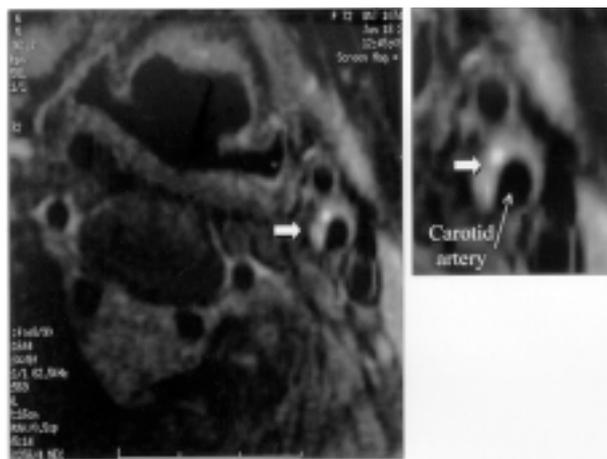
Magnetic resonance image of the left internal carotid artery: a triple inversion recovery-prepared fast spin-echo sequence in the axial plane showing clear evidence of an inhomogeneous hyperintensity due to edema within an asymmetric carotid plaque (arrow). In the right panel a zoom of the carotid plaque is represented.
